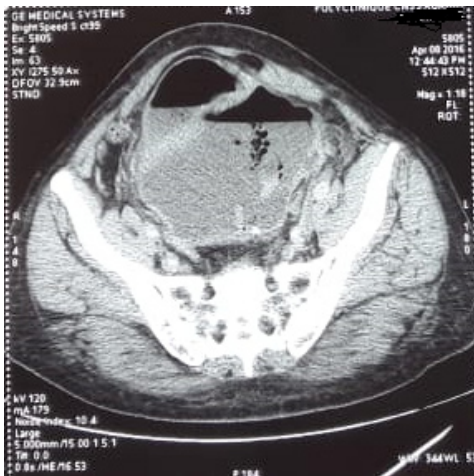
Pelvic computed tomography demonstrating emphysematous changes in the bladder wall.
